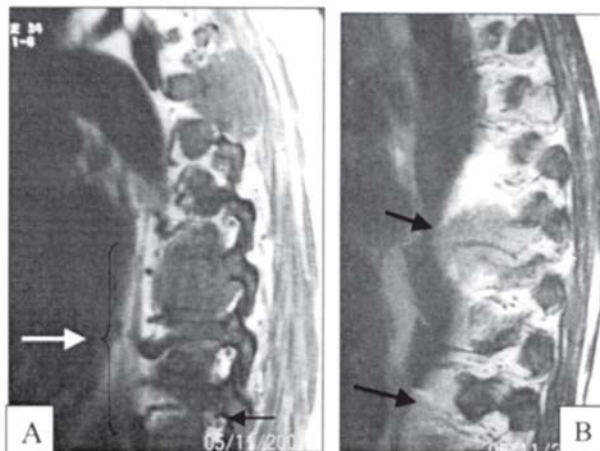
A : MRI of the thoracolumbar region showed multiple lytic lesions of T(4 -7) (white arrow) and 7th posterior rib (black arrow); B: MRI revealed para spinal masses at the T4/T5 and T6/T7
